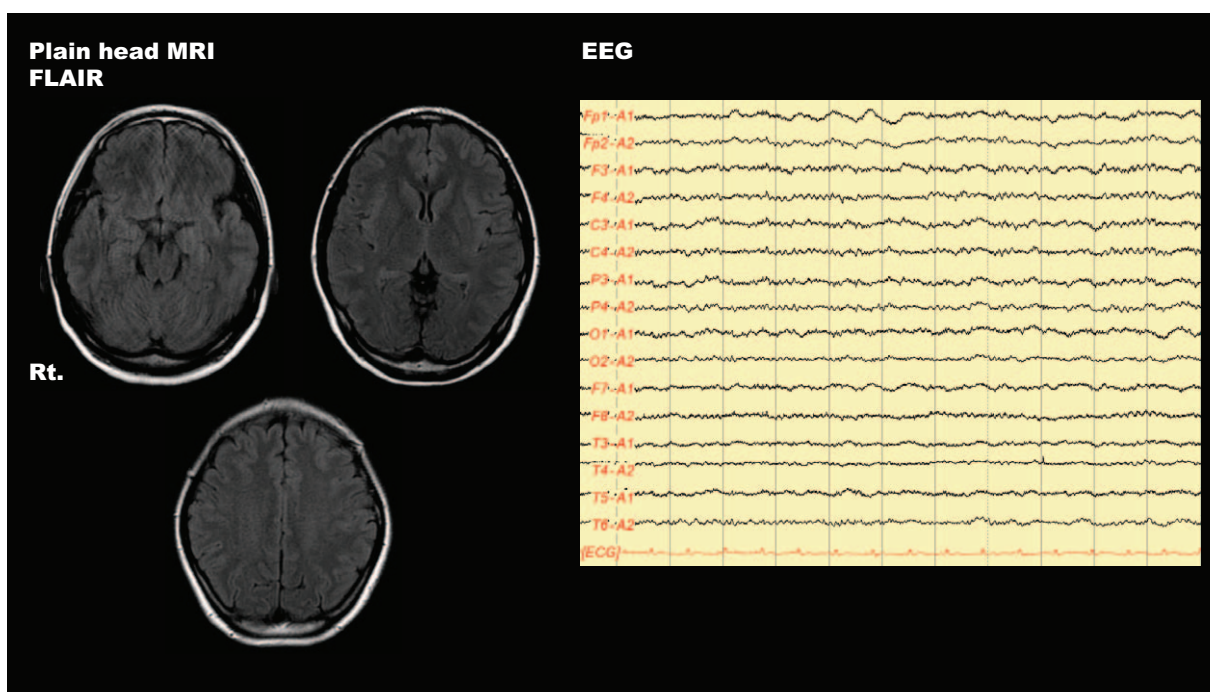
Brain MRI and EEG. Plain head MRI performed on day 2 of hospitalization was unremarkable, and no spike wave was detected on EEG on day 6. EEG = electroencephalography, FLAIR = fluid attenuated inversion recovery, MRI = magnetic resonance imaging, Rt. = right.
